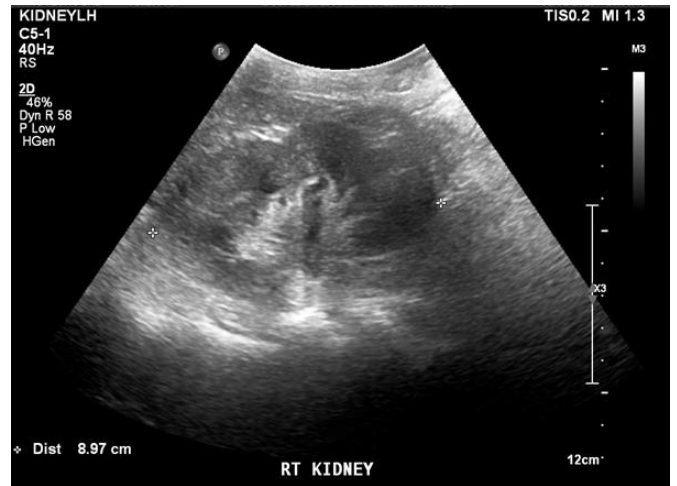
Kidney ultrasound demonstrating a longitudinal view of normal-sized kidneys and a shape with the resolution of hydronephrosis in the right kidney.
